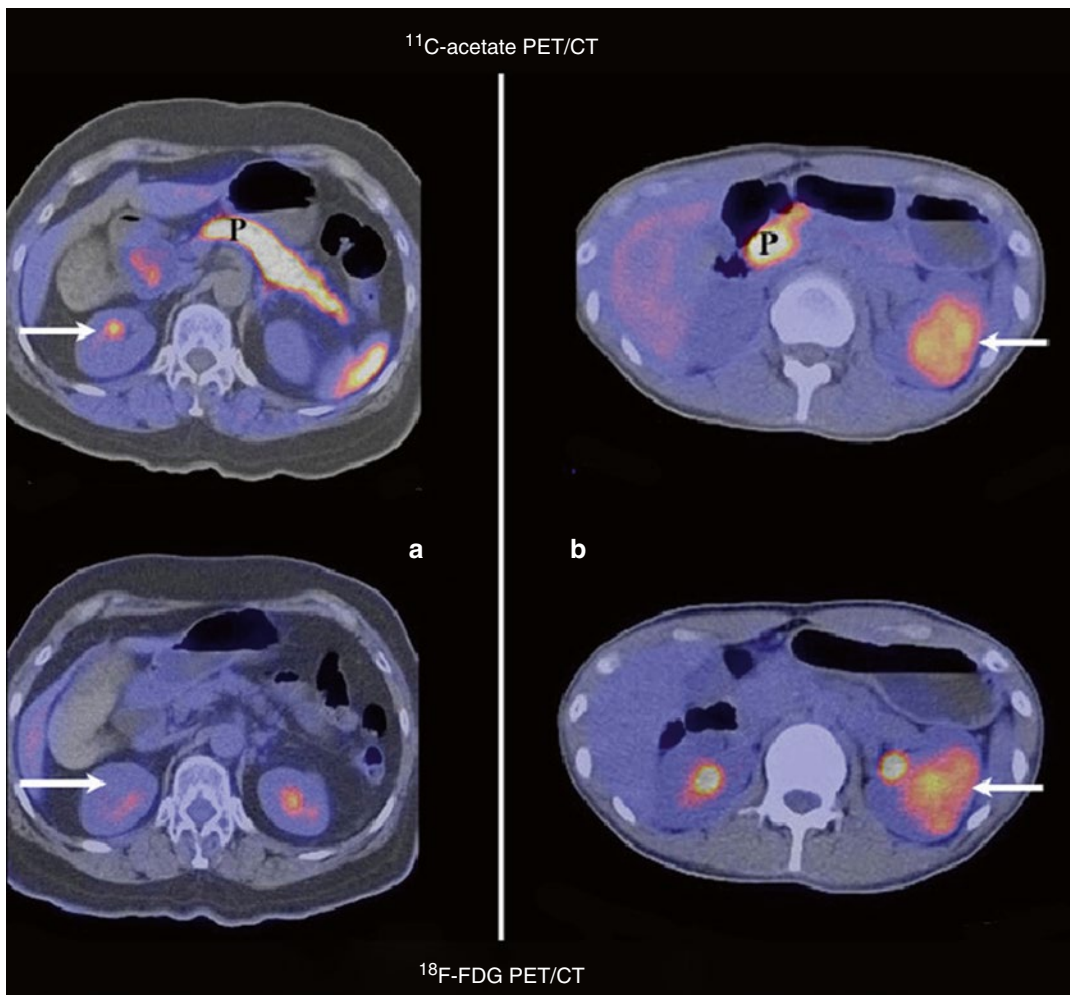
(a) A 1-cm low-grade RCC of clear cell subtype (arrows) is moderately avid for ^{11}C -acetate PET/CT (upper row) but completely negative for ^{18}F -FDG (lower row). (b) A 3.5 cm high-grade RCC of clear cell
